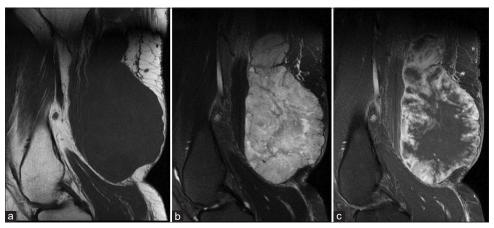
A magnetic resonance image of the tumor over the left popliteal fossa. (a) T1-weighted, (b) T2-weighted, and (c) contrast-enhanced T1-weighted images showing a lobulated mass approximately 6.9 cm × 6.5 cm × 12.7 cm in size, with central necrosis, focal extracapsular extension, and adjacent soft-tissue invasion
